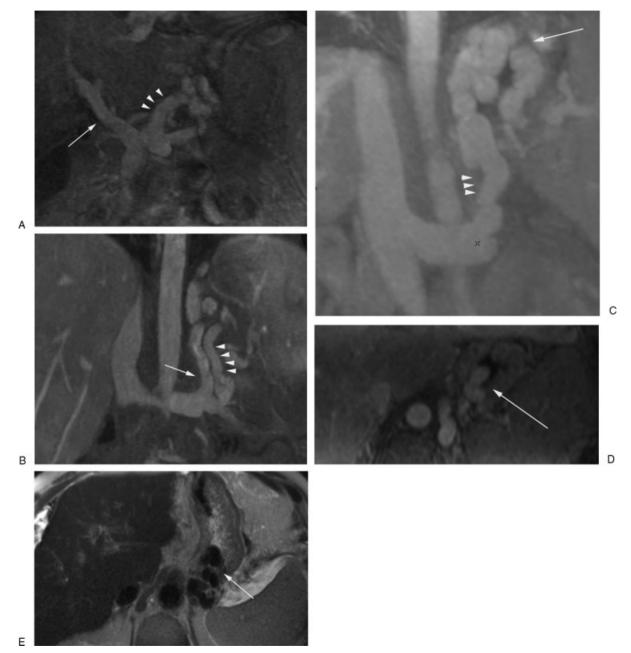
Preprocedural magnetic resonance imaging (MRI). (A) Contrast-enhanced MRI (CEMRI) in the coronal plane showing patency of the portal vein and the left gastric vein (arrowheads) as the main feeding "afferent" vein. (B) CEMRI in the coronal plane showing the posterior gastric vein (arrowheads) as the main feeding "afferent" vein. The gastrorenal shunt is also noted (arrow). CEMRI in the coronal (C) and axial (D) planes showing the gastrorenal shunt (arrowheads) and the opacified gastric fundal varices (arrow). (E) Axial T2-weighted MR image showing the gastric fundal varices as flow voids (arrow).
